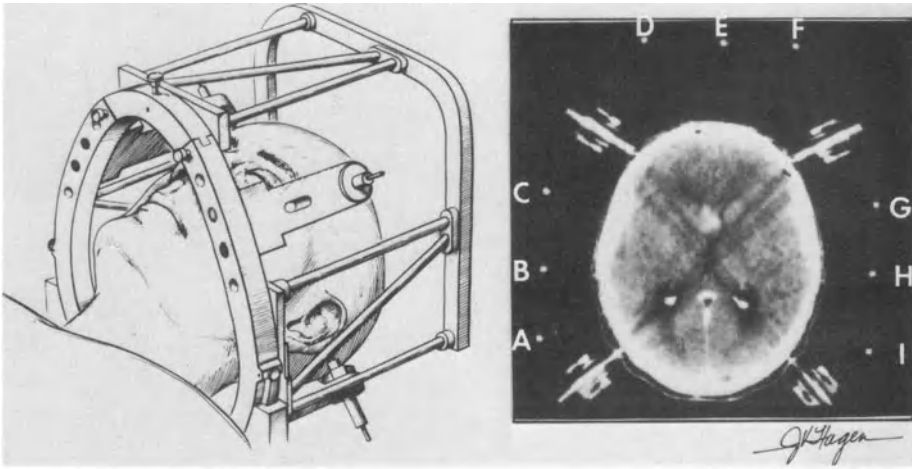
CT localization system (*left*) creates nine reference marks (A-I) on each CT image (*right*).
